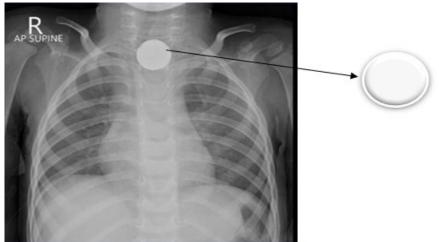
Chest radiograph AP view of the patient
